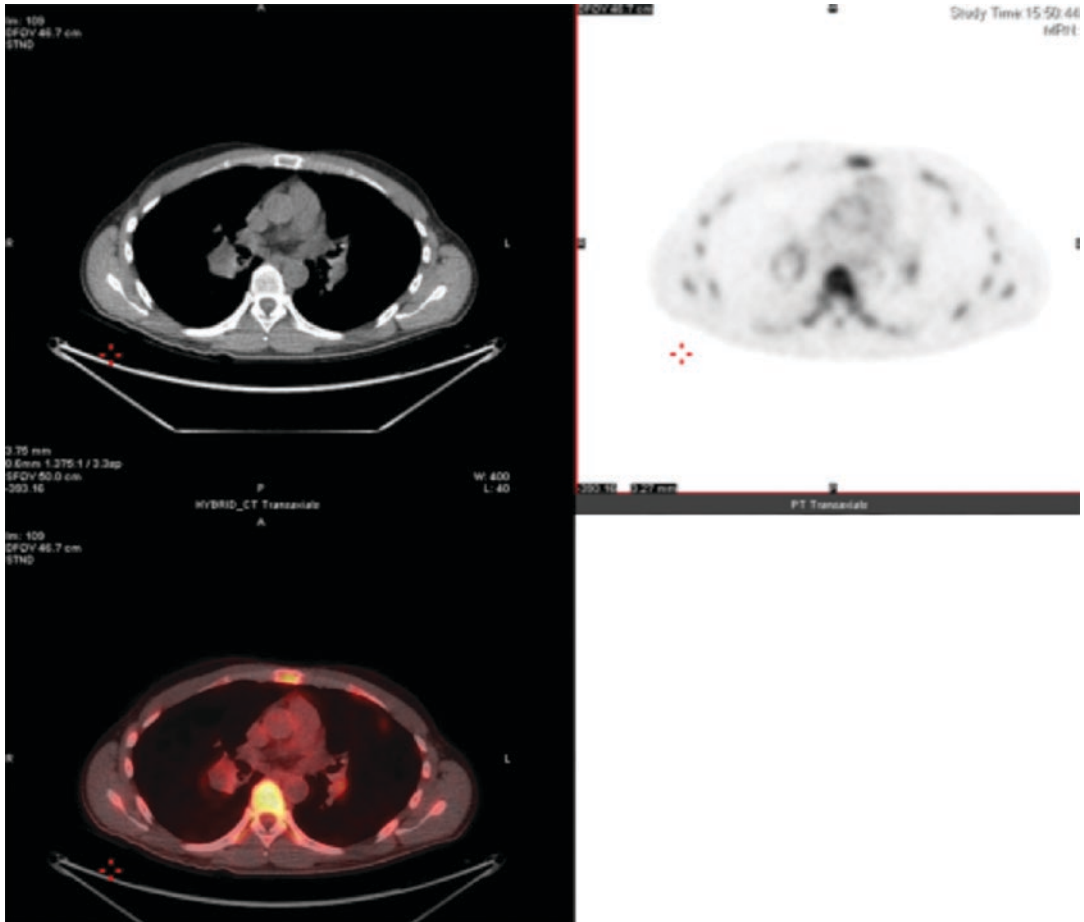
A CT-PET showing large vessel saccular aneurysm of the right pulmonary artery with uptake of FDG, typically seen in Behcet's disease. These aneurysms will regress with therapy. Although tissue confirmation is
